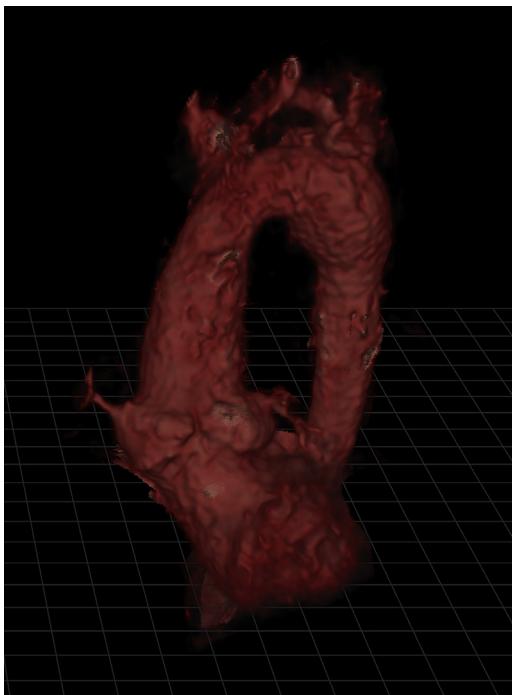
Three-dimensional steady-state free precession MRI in a 39-year-old man with tetralogy of Fallot. Sagittal projection with the right heart removed demonstrates dilatation of the aortic root and ascending aorta, and focal dilatation of the proximal descending aorta. The maximal sinus-to-sinus measurement is 58 mm. (Courtesy of Jimmy Lu, MD, Ann Arbor, MI.)
